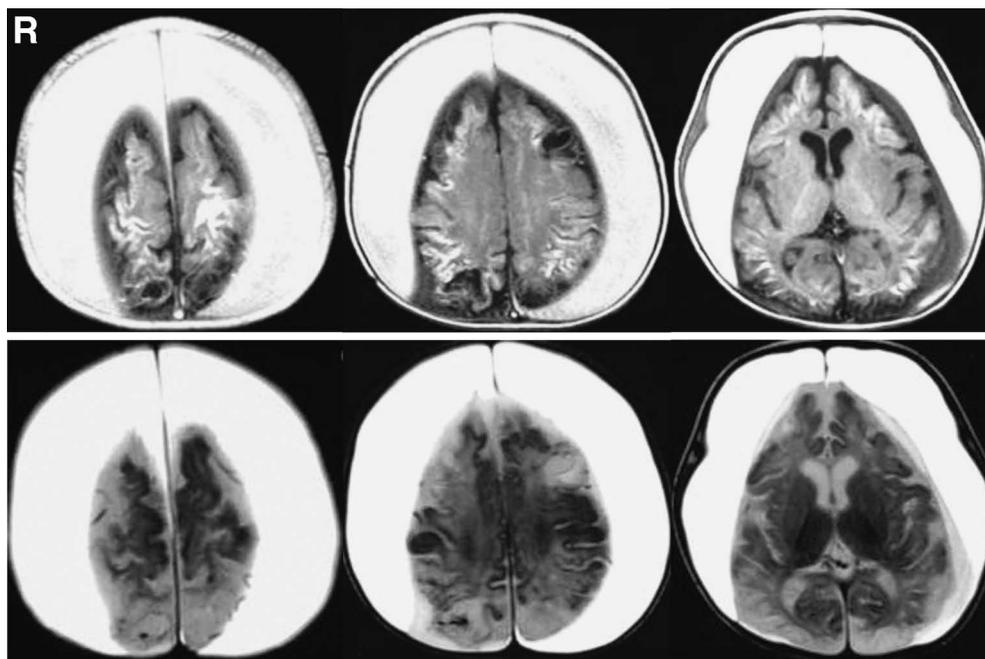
T₁- (upper row) and T₂-weighted (lower row) magnetic resonance images on day 26 revealing diffuse linear hyperintense lesions in the bilateral cerebral hemispheres, suggesting cortical laminar necrosis.
